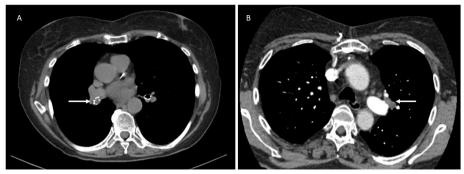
CT images of an intraluminal carcinoid tumor in the right bronchus (A) and an extraluminal carcinoid of the left bronchus (B) (white arrow).
